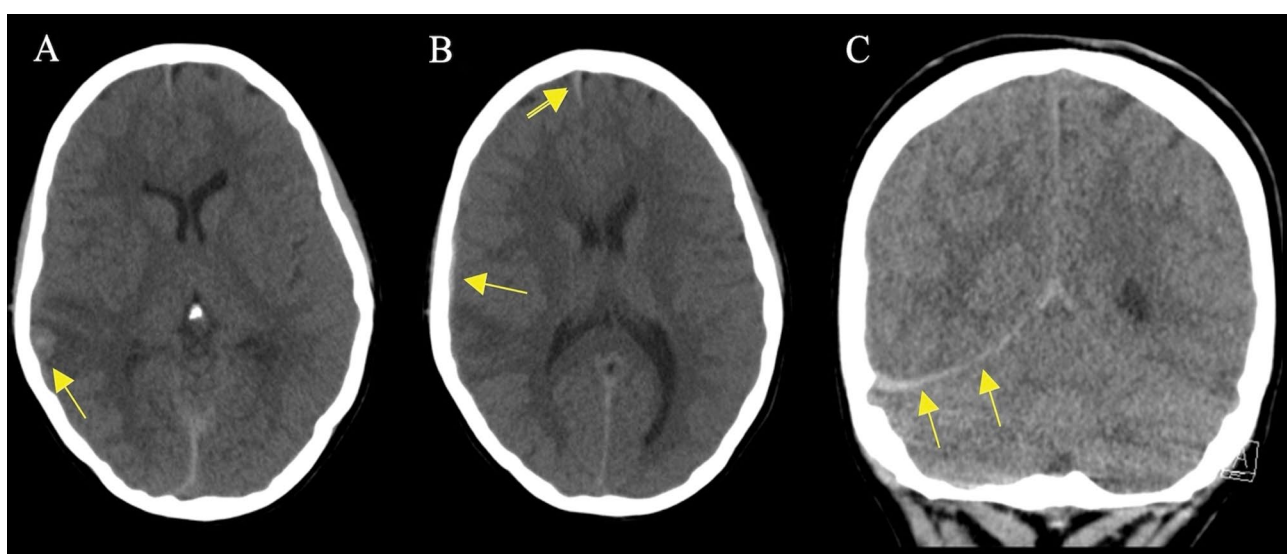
Admission CT reveals hemorrhage (arrow, A) within right temporal lobe contusion on subdural windows. Perilesional edema extends into deep white matter. Thin subdural hematoma (arrow, B) and either small frontal component of subdural or small focus of subarachnoid hemorrhage (double arrows, B) are also detected. Mild midline shift to the left is apparent. No intraventricular hemorrhage is seen on image through dependent occipital horn. Right occipital horn is effaced. Soft tissue window of coronal multiplanar reformatted image reveals tentorial subdural hemorrhage (arrows, C) and effacement of right occipital horn. Bone windows (not shown) do not reveal temporal bone fracture.
